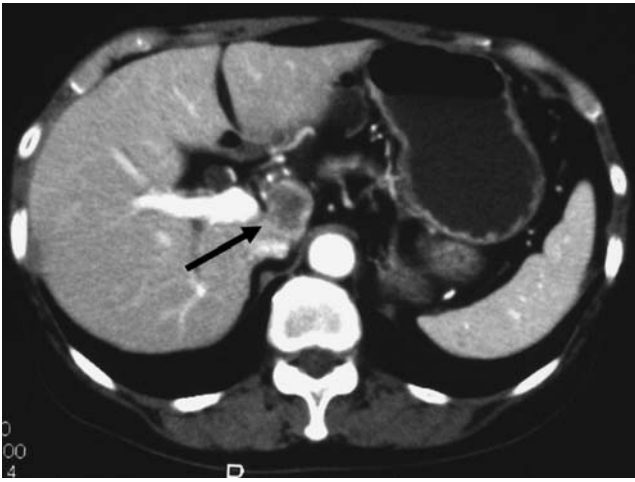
Preoperative computed tomography shows a low-density mass with peripheral enhancement and calcification adjacent to the pancreatic head and caudate lobe of the liver (arrow).
